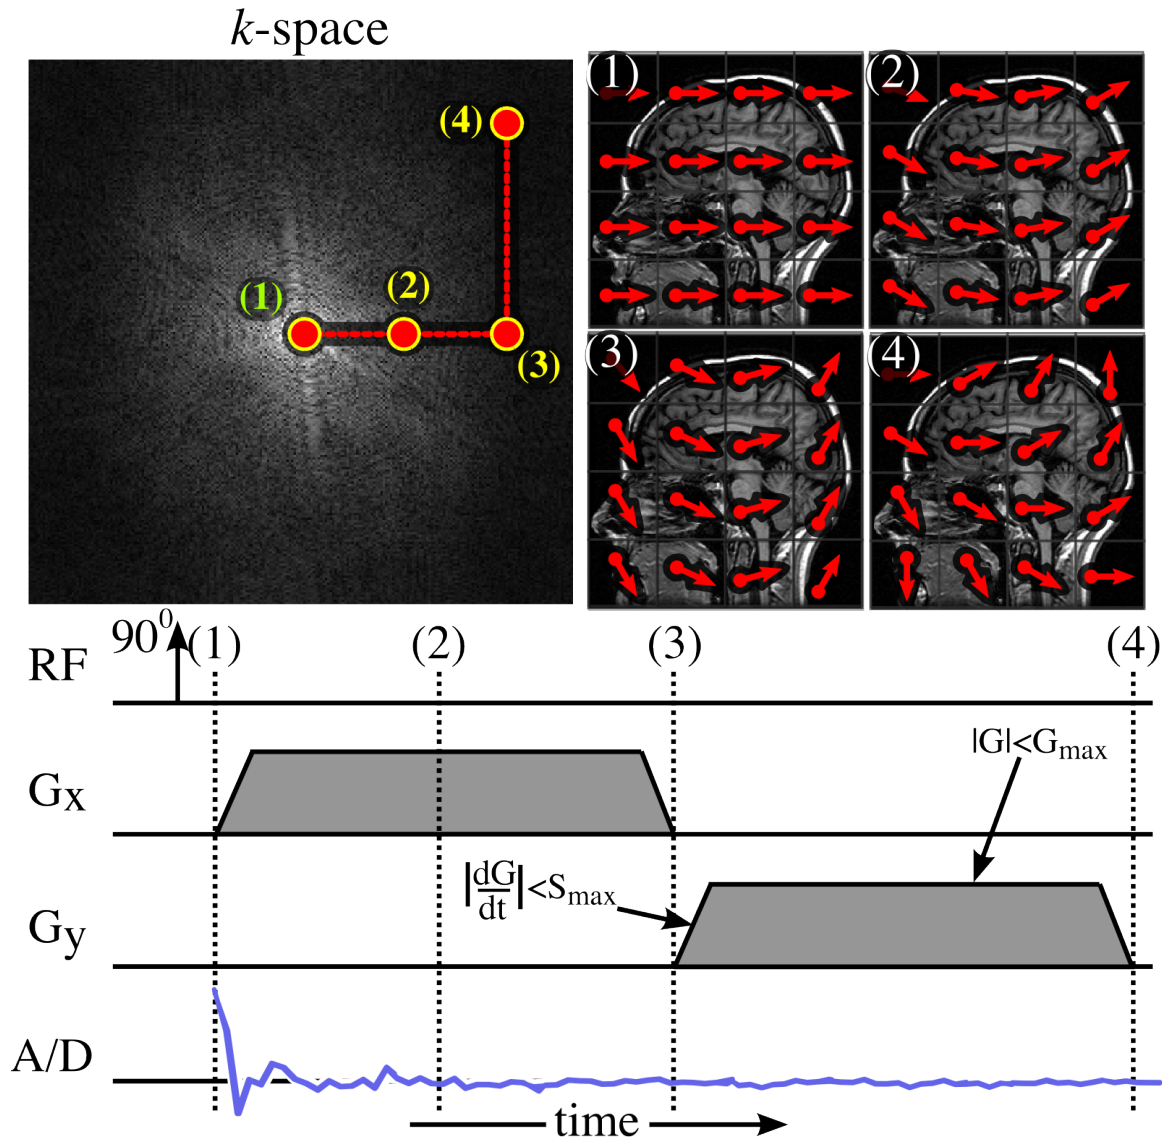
Fourier spatial encoding. The temporal MRI signal directly samples the spatial frequency domain of the image. Gradient fields cause a linear frequency distribution across the image, which produces a linear phase accrual with time. The received signal samples are spatial frequencies of the image. The corresponding spatial frequencies are proportional to the gradient waveform area. The gradient is limited in amplitude, G_{max} , and slew rate, S_{max} , which are both system specific.
